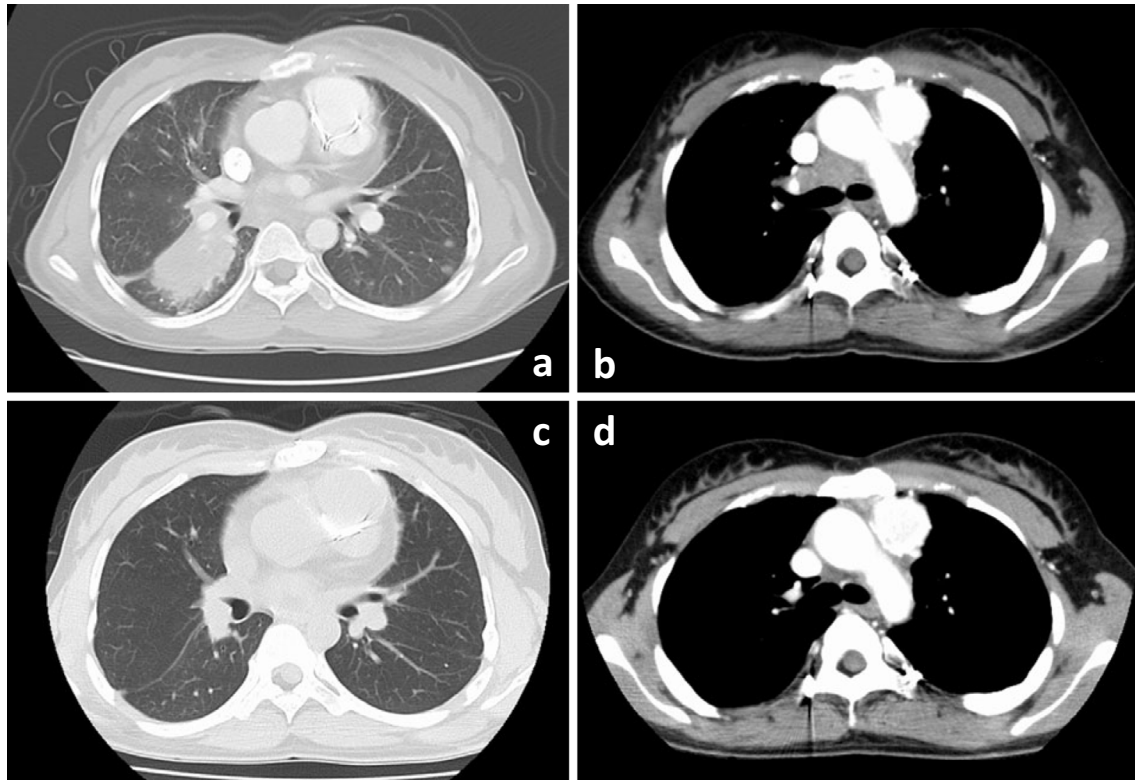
Chest computed tomography (CT). (a, b) CT on the first visit, showing a right lower lobe mass, multiple nodules in both lungs, and multiple mediastinal lymphadenopathies. (c, d) Chest CT at 2 months after diagnosis, showing SR of the tumor and lymphadenopathies. SR: spontaneous regression
